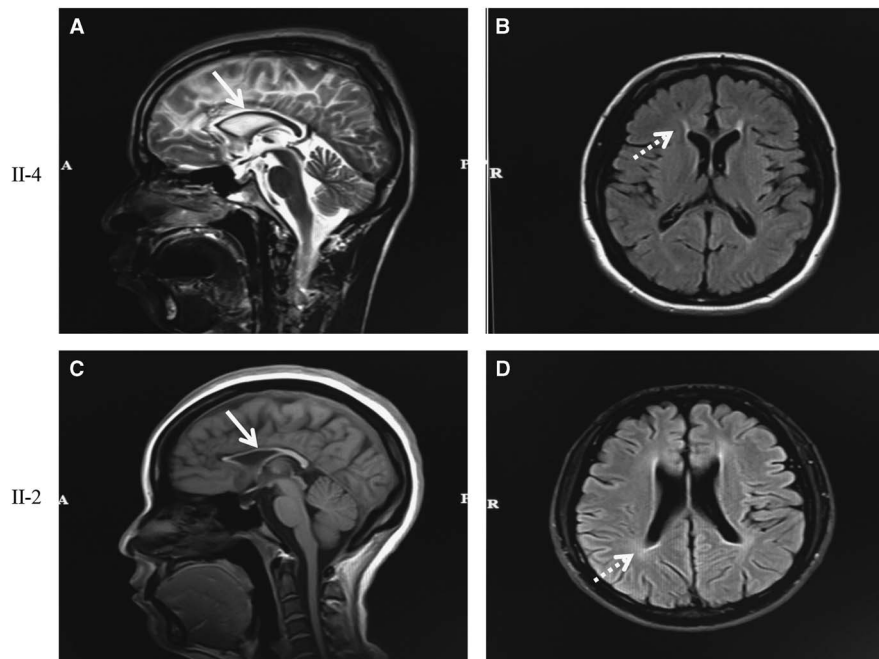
MRI features of the brain in patients II-4 and II-2. Both patients showed thinning of the corpus callosum on sagittal T2-weighted imaging (A) and sagittal T1-weighted imaging (C) images (arrow). Periventricular leukoaraiosis was found symmetrically in the anterior and posterior horn on fluid-attenuated inversion recovery imaging (B and D, dotted arrow).
